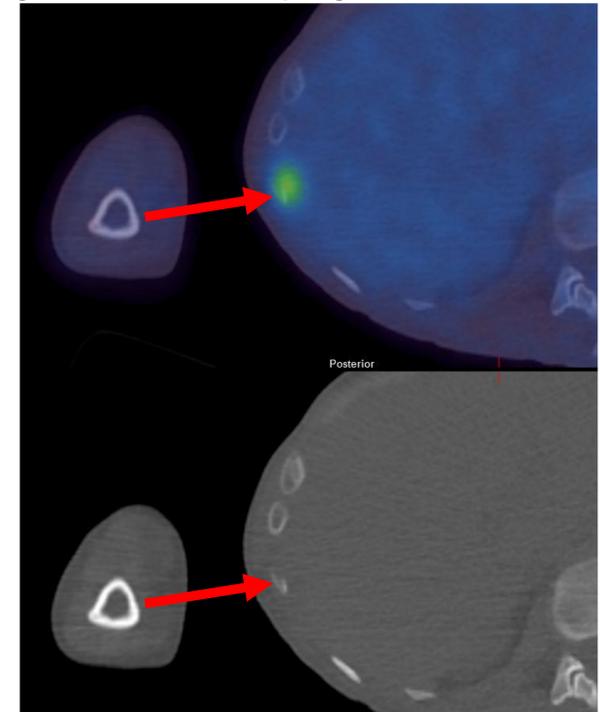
FDG avid lytic bone metastasis right 10<sup>th</sup> rib
